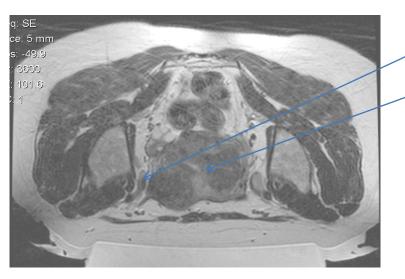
Category 1 Fibroid Uterus on axial MR image
